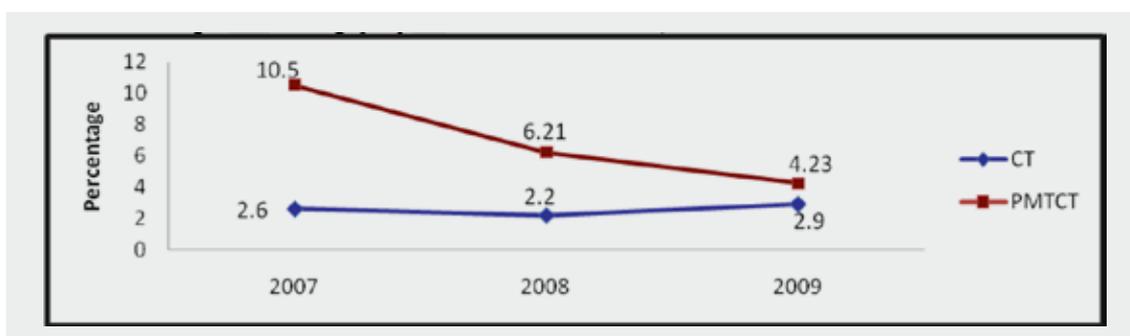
Proportion of HIV sero-positive individuals among people who participated in counselling and testing (CT) and PMTCT activities, 2007-2009
